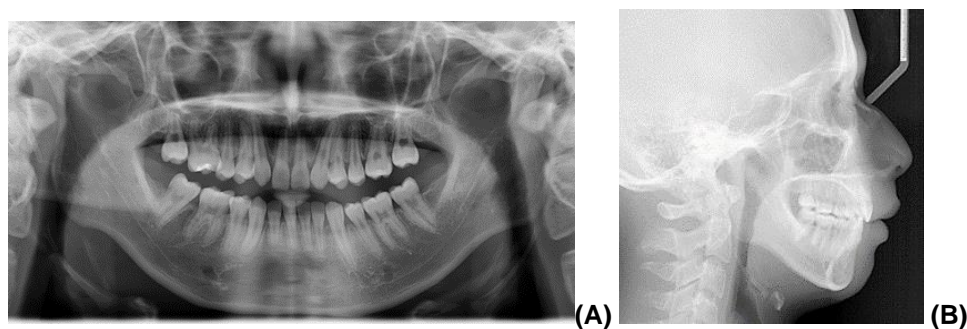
Final radiograph. (A) panoramic x-ray. (B) Cephalometric x-ray. radiographic films
